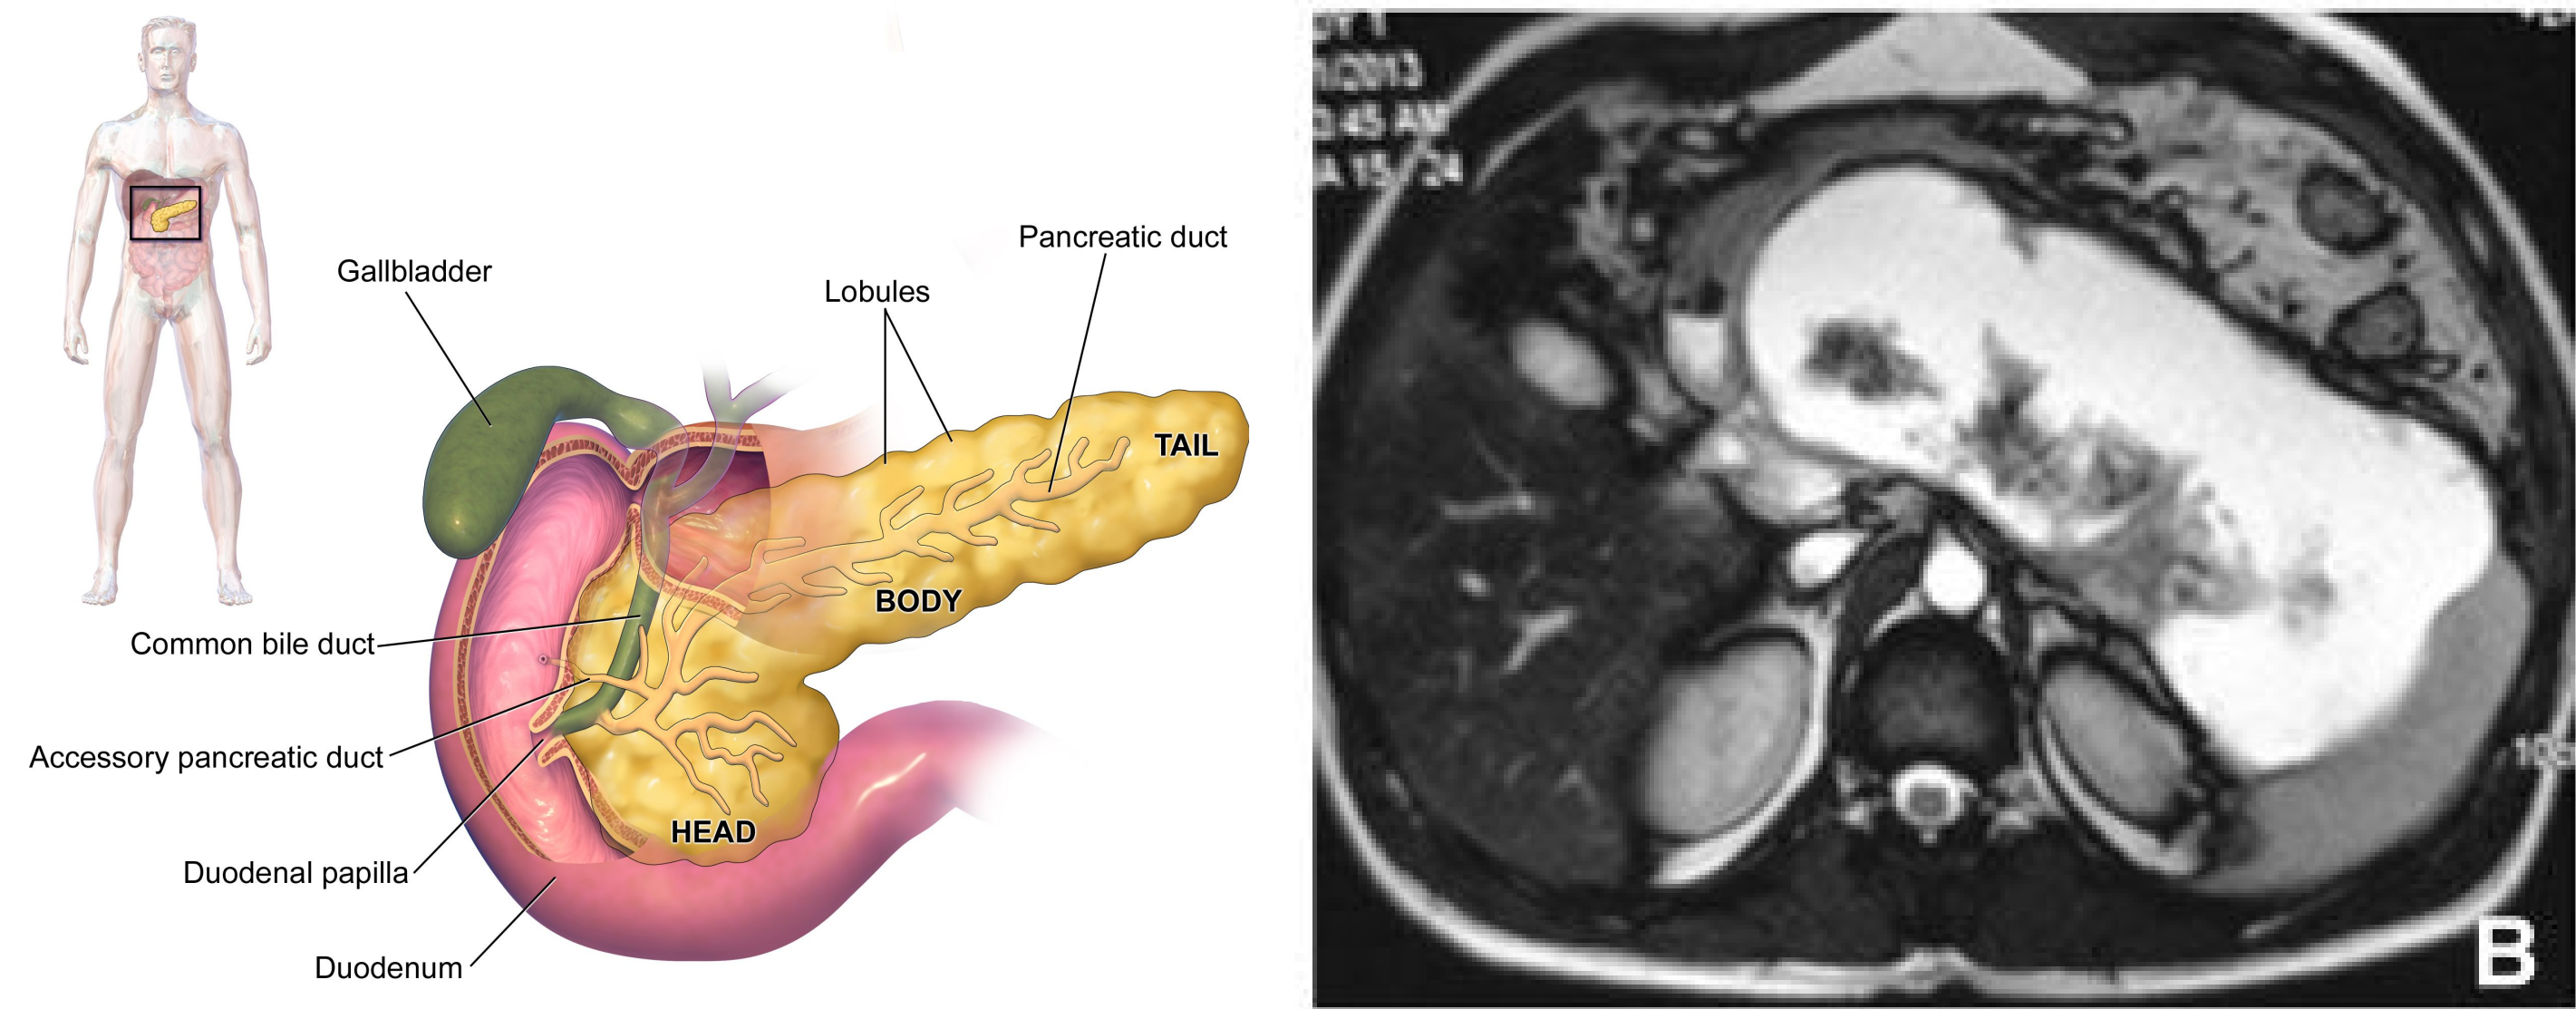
On the left, the anatomy of a human pancreas can be seen. On the right, a CT scan of a patient with Necrotizing Pancreatitis is shown with the liquified contents of the cyst showing bright white.^{1,2}
